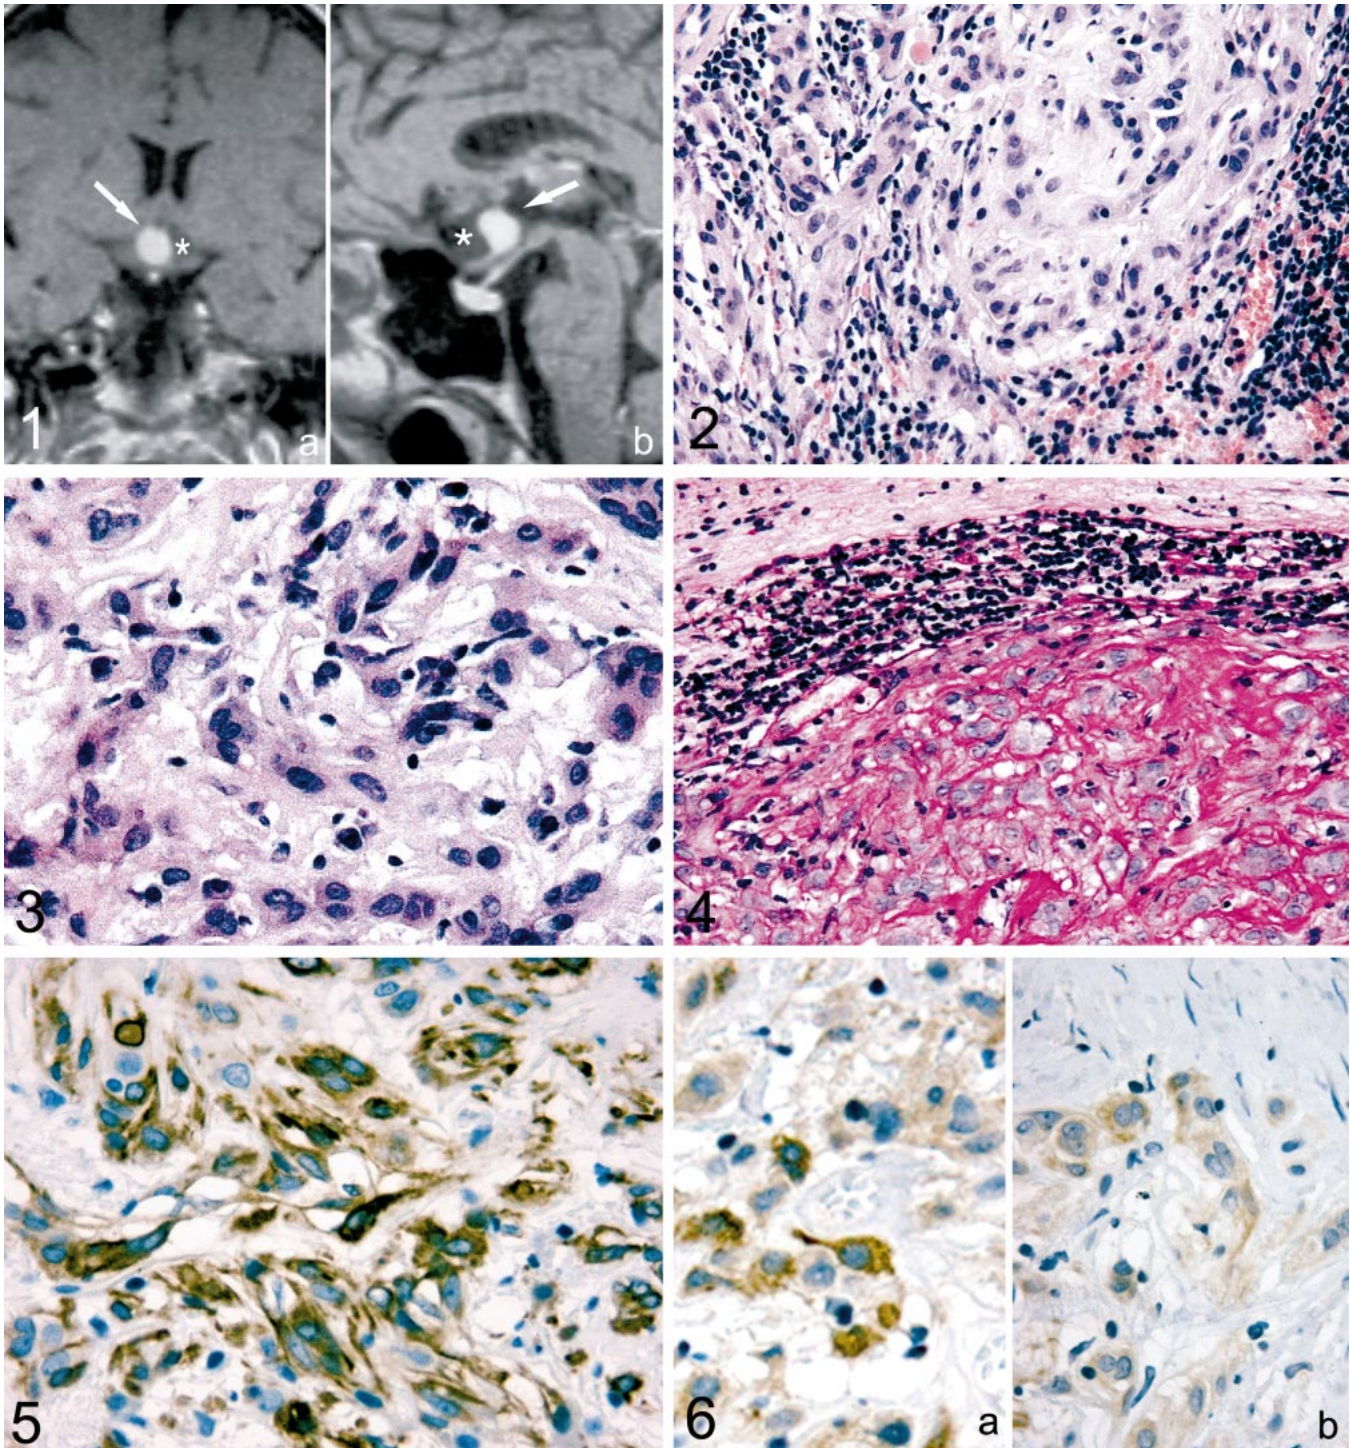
Well-demarcated and partially cystic mass (asterisk) homogeneously enhancing in its solid area (arrows) (coronal [a] and sagittal [b] contrast-enhanced magnetic resonance images).
